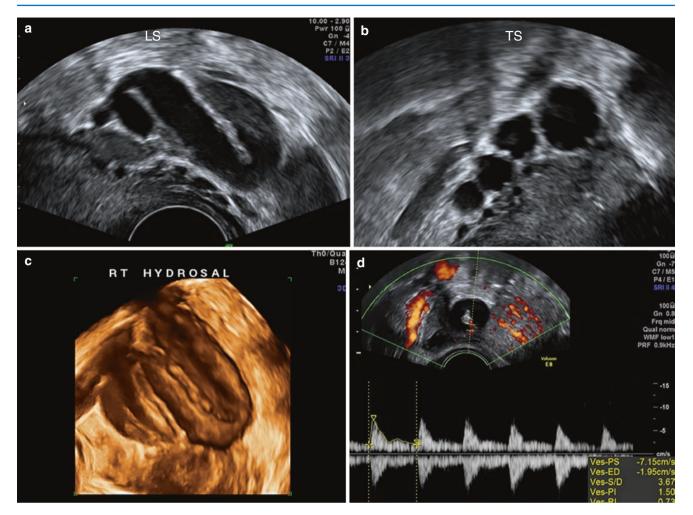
(a) Long section of a hydrosalpinx showing incomplete septae and anechoic cystic contents. (b) Transverse section of the hydrosalpinx perpendicular to the section in image (a), showing multiple, circumscribed, cystic areas with anechoic contents and beaded thin walls. (c) 3D rendered image of the hydrosalpinx. (d) Minimal flow with spectral Doppler showing protodiastolic notch (which is typical of tubal tissue flows)
